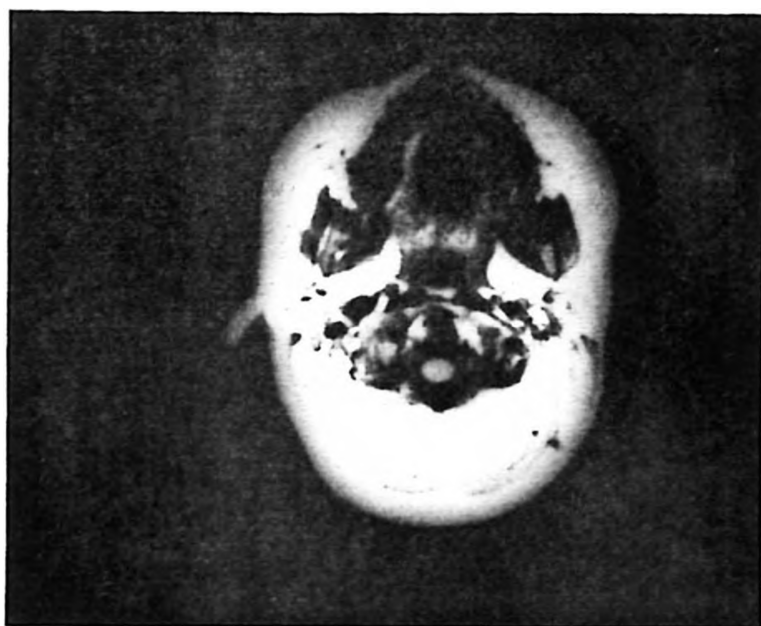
MRI of a 10-year-old girl with an 8-year history of systemic JRA. Periodontal pannus formation and erosion of odontoid process.
